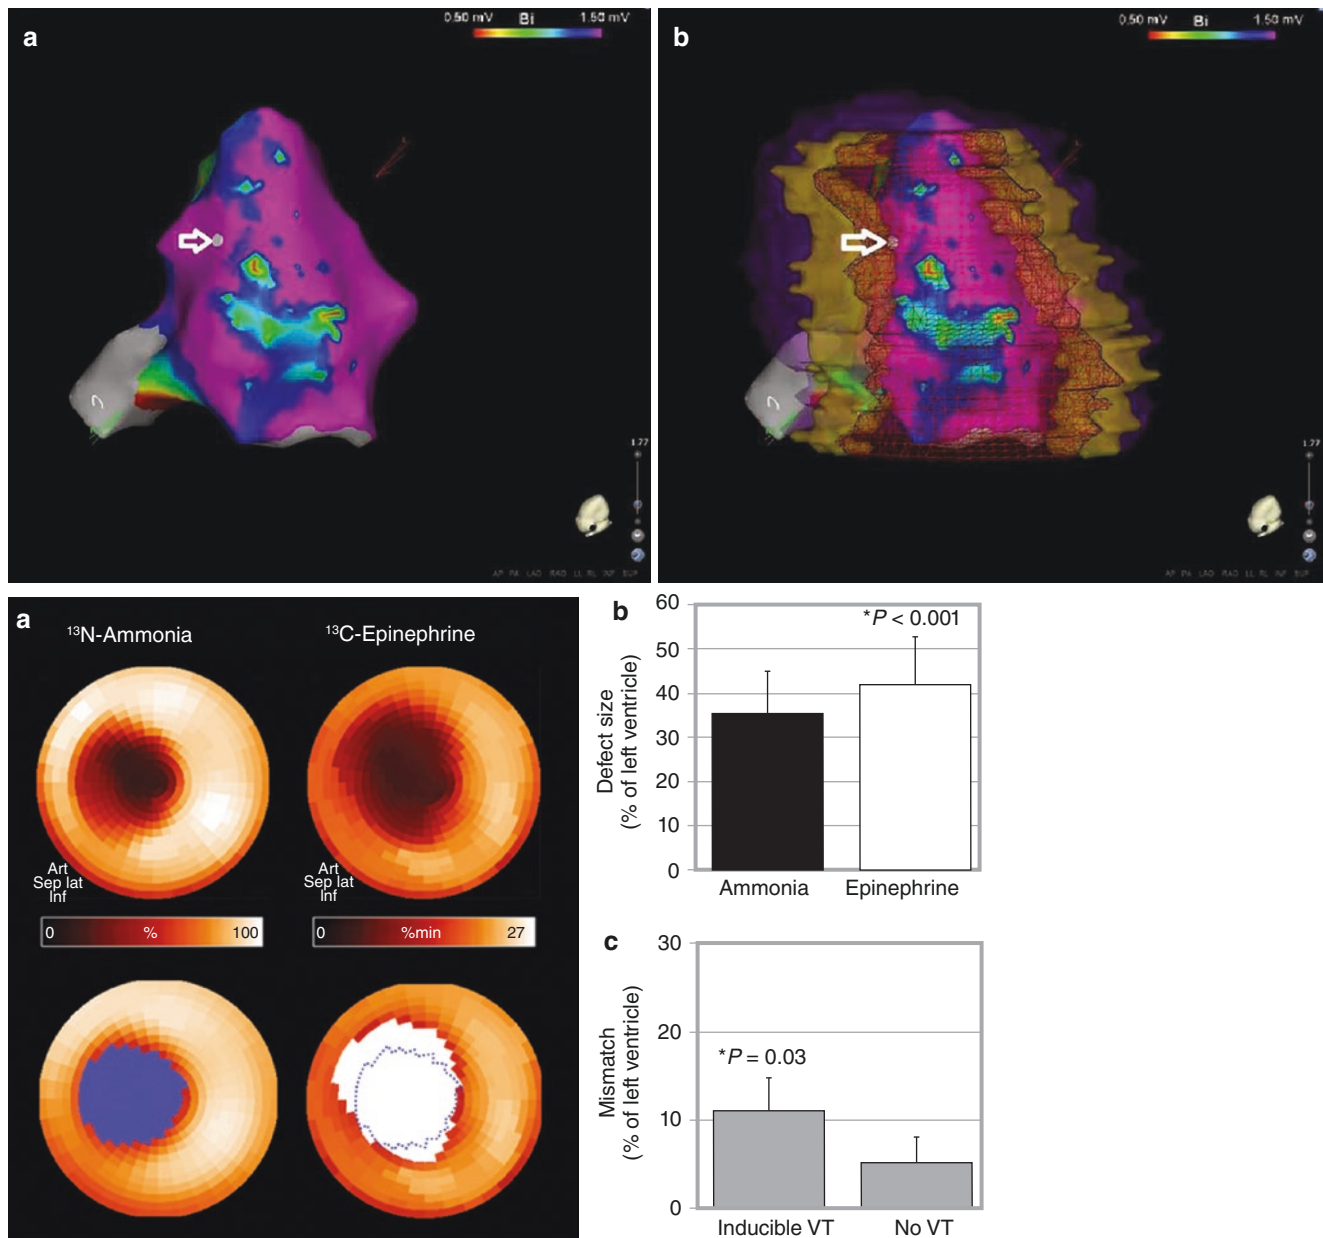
PET and SPECT innervation tracers have been used to study the border zone surrounding myocardial infarct, a region believed to be arrhythmogenic. In a quantitative analysis of ^{123}I -mIBG SPECT images from coronary artery disease patients who underwent electrophysiology testing, the best predictor of VT inducibility was ^{123}I -mIBG uptake in the border zone (area under ROC = 0.78)—better than MPI scar extent or border zone extent [51]. In a prospective study of 15 patients referred for ischemic VT ablation and studied with ^{123}I -mIBG SPECT and high-density voltage mapping [52], ^{123}I -mIBG innervation defects were about 2.5-fold larger than bipolar voltage-defined scars, all VT ablation sites were within areas of abnormal innervation, and 36% of successful ablation sites demonstrated normal voltages (>1.5 mV). (a) In this example of a discordant preserved voltage-denervation location of a successful ablation site, the bipolar electroanatomic map, inferior view (A), demonstrates inferior scar with ablation site (yellow dot; white arrow) at an inferior septal location within the area of preserved bipolar voltage (>1.5 mV). Coregistration of the electroanatomic bipolar
